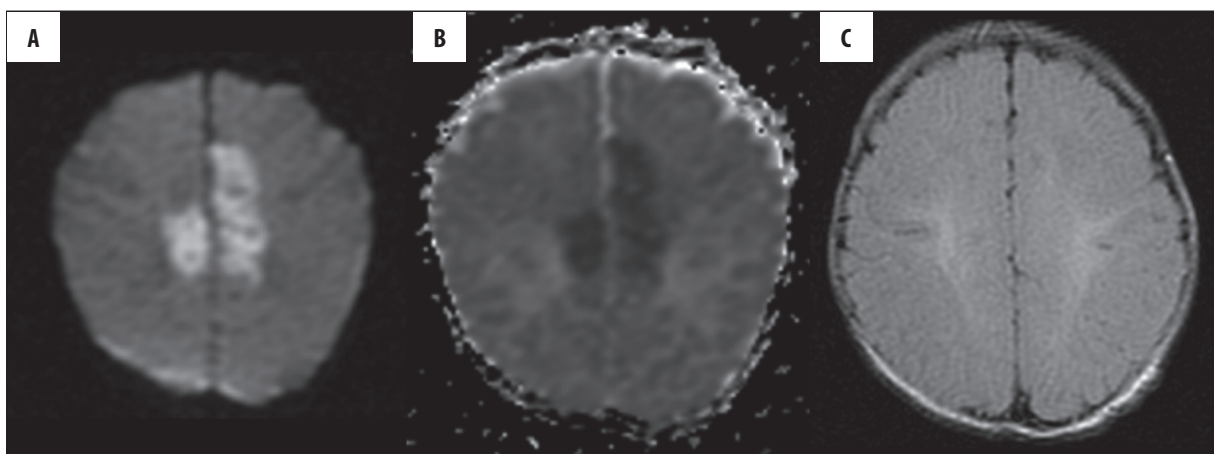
Acute, parasagittal brain injury, visible only in the DWI sequence. (A) DWI; (B) ADC; (C) FLAIR – undetectable lesions.
